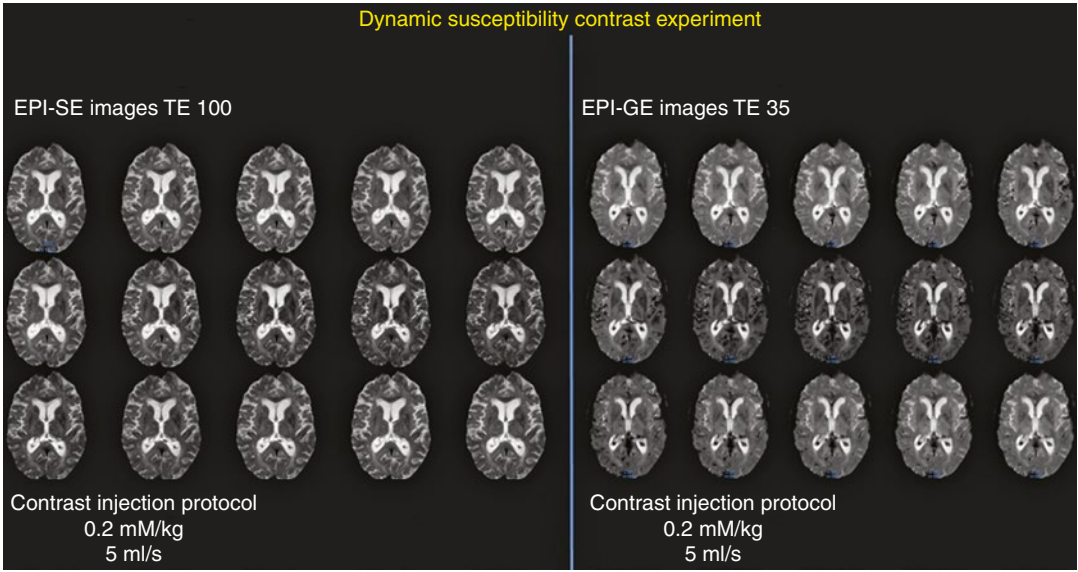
T2- and T2*-weighted echo-planar MR image of the same slice show decreased signal intensity of brain parenchyma while bolus of paramagnetic contrast material passing through the tissues. The reduction of signal intensity is greater within the gray matter than in the white
